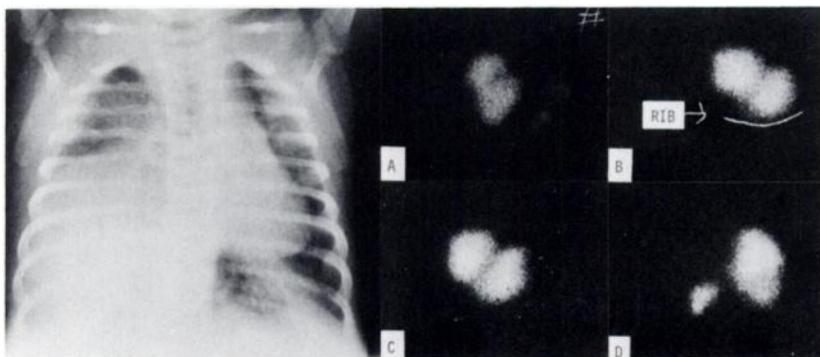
Chest x-ray and liver scintigram of 4-week-old infant. Chest x-ray obtained after thoracocentesis. Note marked elevation of "right hemidiaphragm." Liver scintigram: (A) Anterior view: note indentation and "band" dividing liver into two portions. (B) Right lateral view: "band" divides liver into superoposterior and inferoanterior portions. "RIB" indicates lower costal margin. (C) Right anterior oblique view: note "hamburger" appearance of liver. (D) Posterior view: note that herniated portion is much higher than spleen and appears more distinct in contrast to weaker inferior portion, which is farther away from camera.
